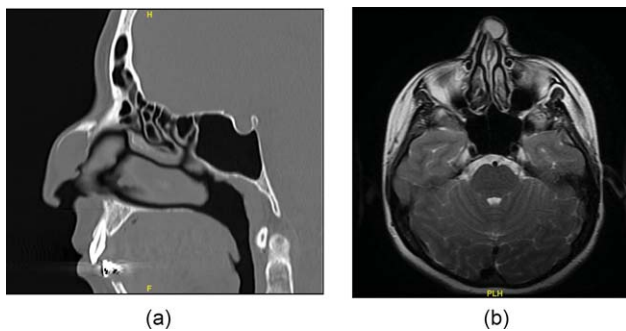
A cystic mass remodeling in the bone is seen in computed tomography (a) and magnetic resonance imaging (b).
